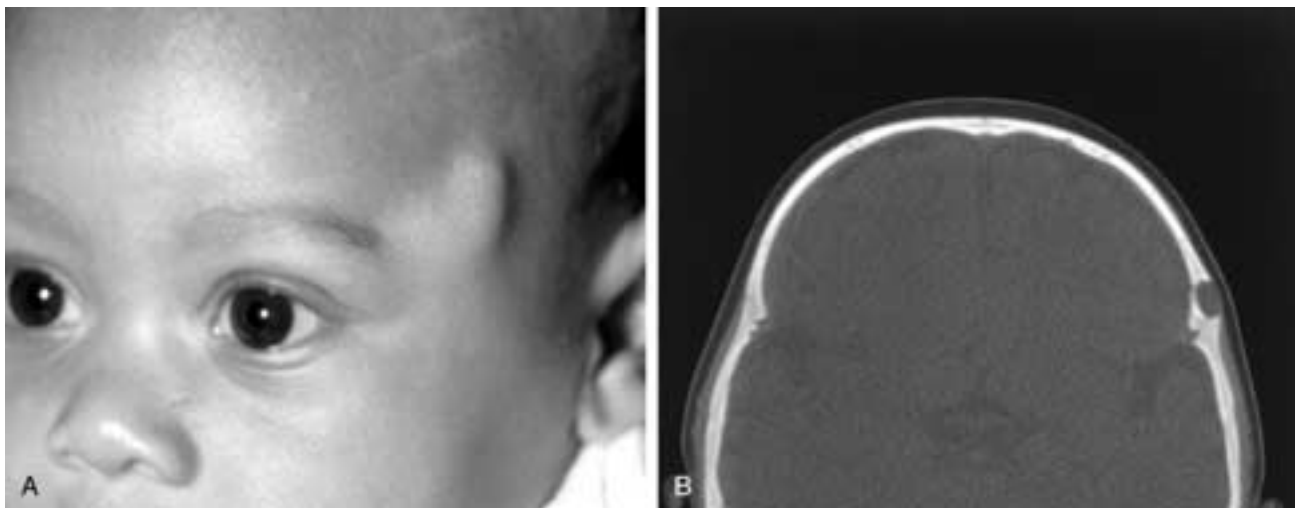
Left frontotemporal dermoid. Two patients. A, Infant boy with a soft-tissue “bump” close to the pterion. B, Noncontrast axial bone algorithm CT displays a sharply margined, slightly expansile dermoid abutting onto the coronal suture.
